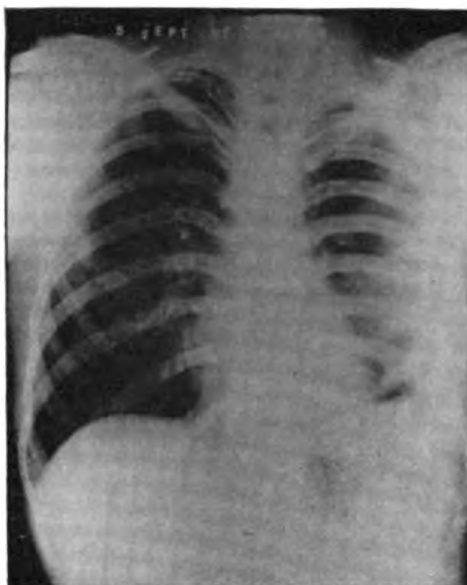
Case 5. Roentgenogram showing obliteration of the residual empyema cavity following 3 weeks of suction drainage. Pleural thickening is marked.
